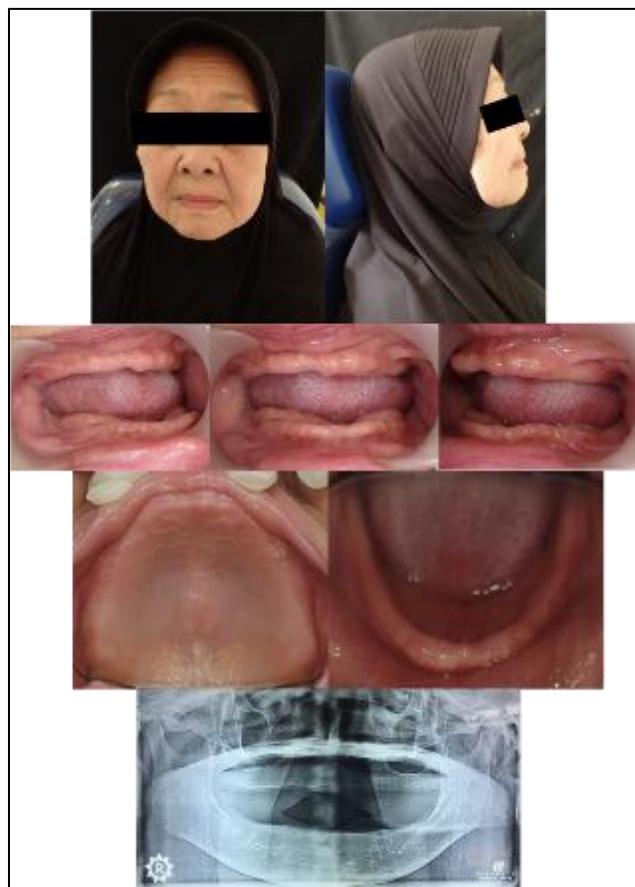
Pre-treatment extra-oral and intra-oral views and panoramic radiograph showing complete edentulism of the maxillary and mandibular arches with reduced lip support
